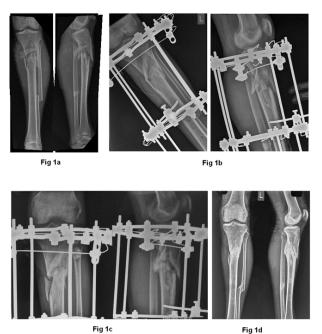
19-year-old male with grade II open, comminuted, Extra-articular proximal tibia fracture, a) Pre-operative radiograph of tibia Antero posterior and lateral View b) postoperative radiographs showing correction of alignment c) 3.5 moths post-operative radiograph showing progressive union at the fracture site; d) 6 months after ring removal radiographs showing well united fracture in good alignment.
